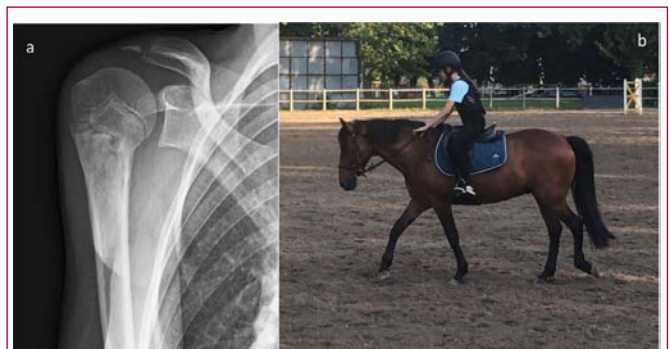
Four months follow-up. a) at 4 months follow-up, anteroposterior radiographs of the right shoulder showing partial obliteration of the physis with no sign of avascular necrosis. b) the girl had resumed riding.
